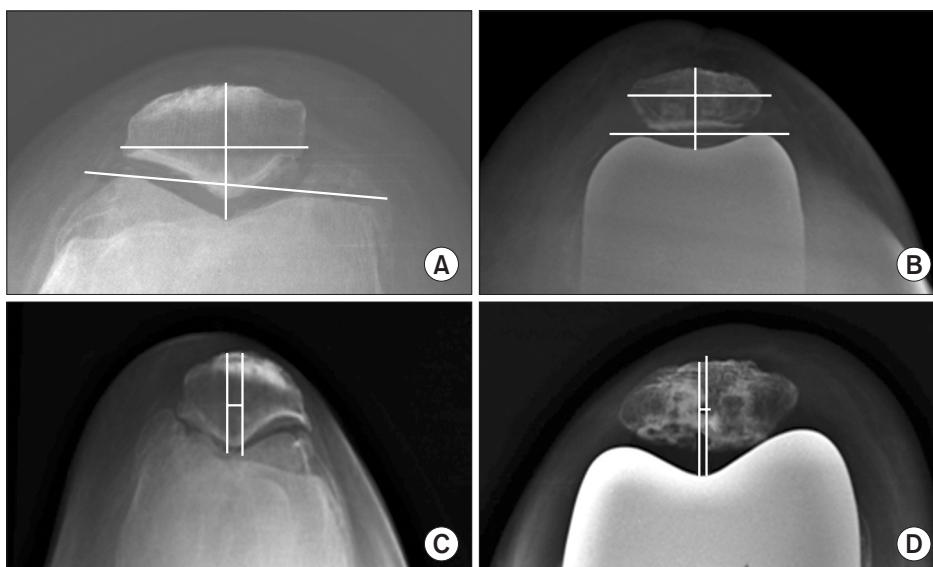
Radiographic analysis of the patellar skyline view showing pre- and postoperative patellar thickness and tilt (A, B) and patellar displacement (C, D).
